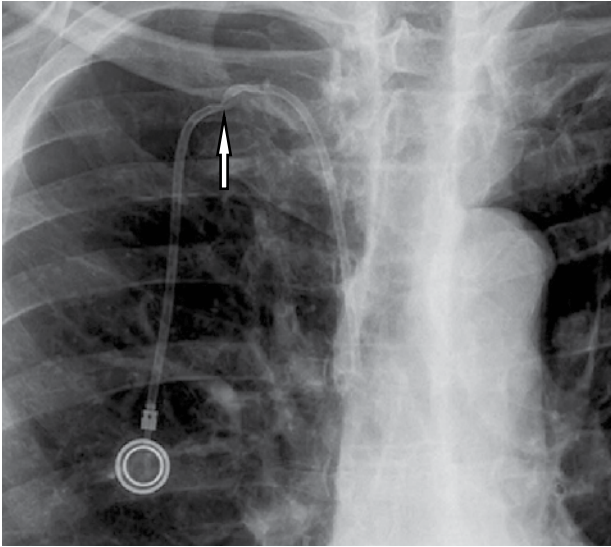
Chest X-ray showing a port-a-catheter infusion system inserted via the right subclavian vein, which is seriously twisted and nearly broken off at its middle portion in the infraclavicular region.
